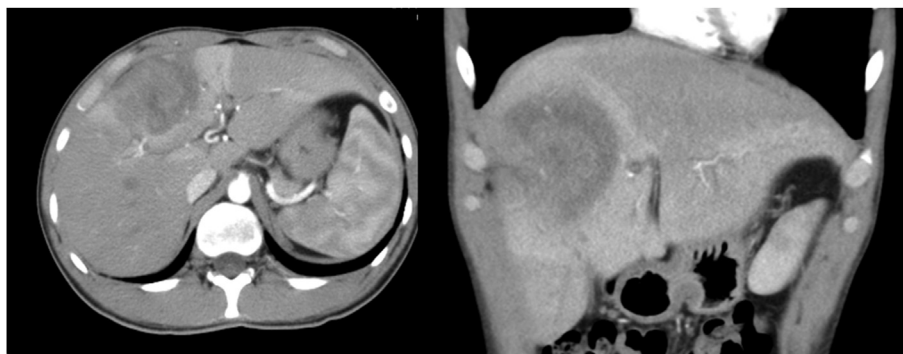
Enhanced computed tomography (CT) showed abscess mainly in S4 and S8 with peripheral ring enhancement and central hypodensity measuring 9 cm in the craniocaudal dimension.
